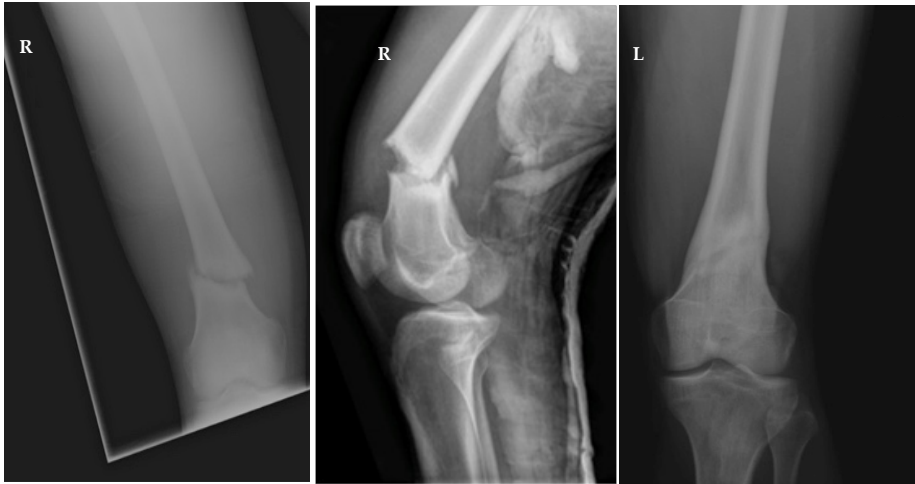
Radiographs at presentation. A,B) Right, AP and lateral (respectively), distal femur, oblique supracondylar fracture. C) Left, AP, oblique lucency in the supracondylar region, circumferential cortical thickening.
